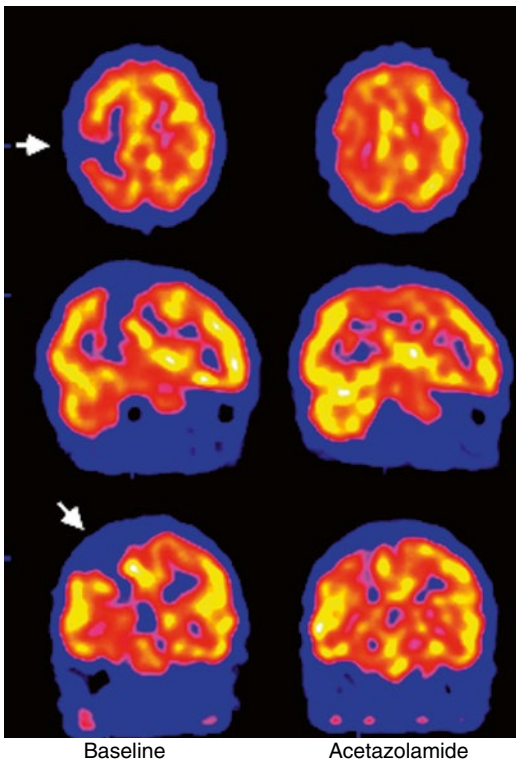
Patient with moyamoya. The baseline ^{99m}Tc -ECD SPECT reveals markedly focal decreased perfusion (arrows). A repeat SPECT following the administration of acetazolamide reveals improved perfusion in the affected regions. This patient was considered a good candidate for revascularization
